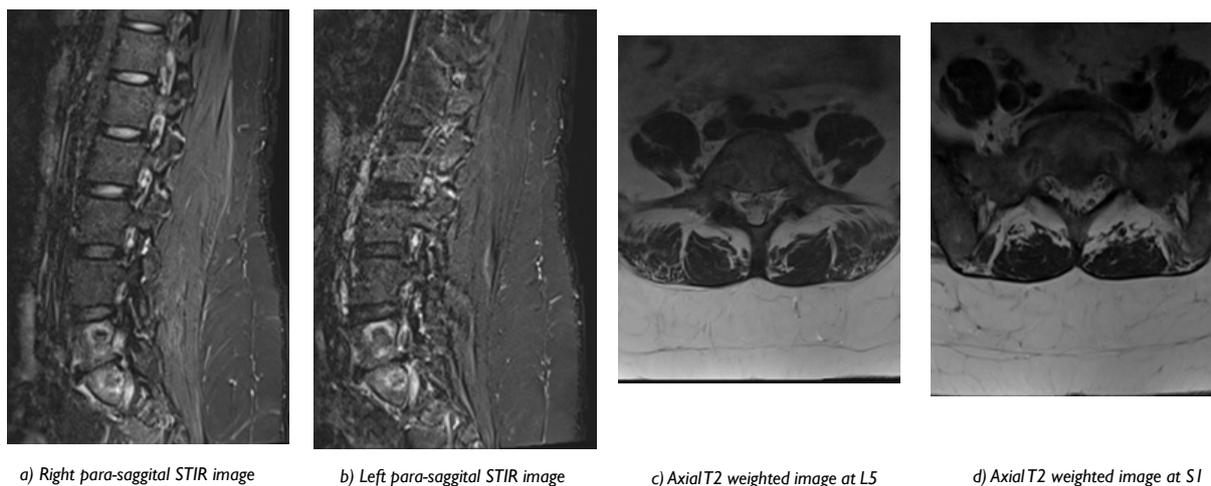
6-weeks Post-BVNA MRI Images, Demonstrating New Sclerosis Consistent with BVNA Lesions
